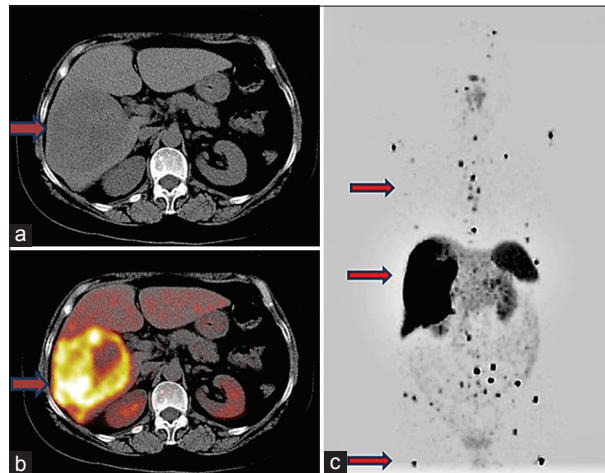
68-Ga-DOTANOC positron emission tomography-computed tomography shows somatostatin receptor expressing tumor in both lobes of liver with extensive skeletal metastasis (a-c; transaxial computed tomography, positron emission tomography-computed tomography and maximum intensity projection images, respectively)
